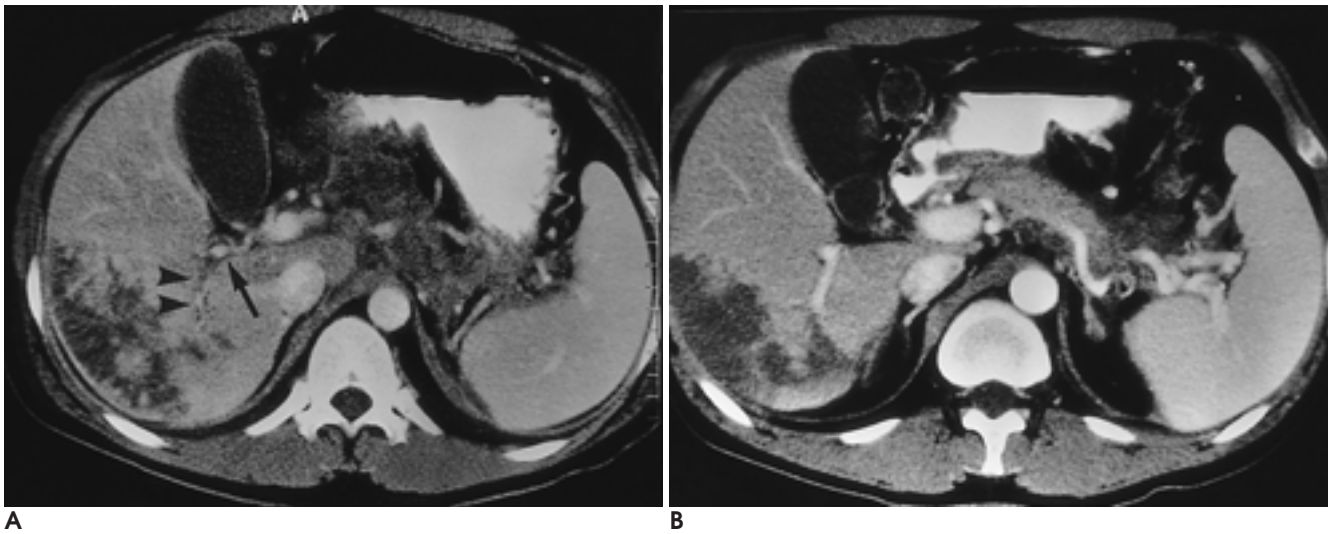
Initial CT scans.
